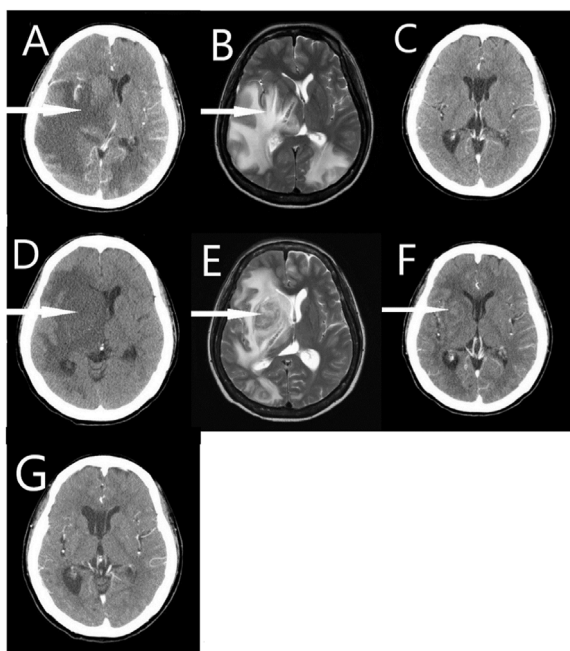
(A) Brain CT (2013/09/07) and (B) brain MRI (2013/09/09) showed huge ill-defined lesions in bilateral cerebrums (more prominent over the right one) with brain swelling and midline shift to the left; (C) regressive brain lesions in follow-up CT (2013/12/27). (D) Brain CT (2016/03/22) and (E) MRI (2016/03/24) showed an ill-defined mass (about 36 × 27 mm) over the right basal ganglia; (F) evolutionary brain CT imaging (2016/04/14) was found after 3-week antitoxoplasmic treatment, and (G) brain CT imaging (2018/01/05) found 21 months later.
